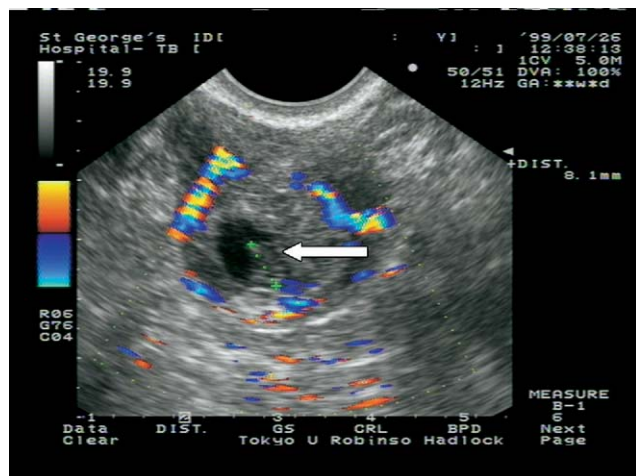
Nonviable tubal ectopic pregnancy at color Doppler. Solid arrow points at fetal pole. (Color version of figure is available online.)
